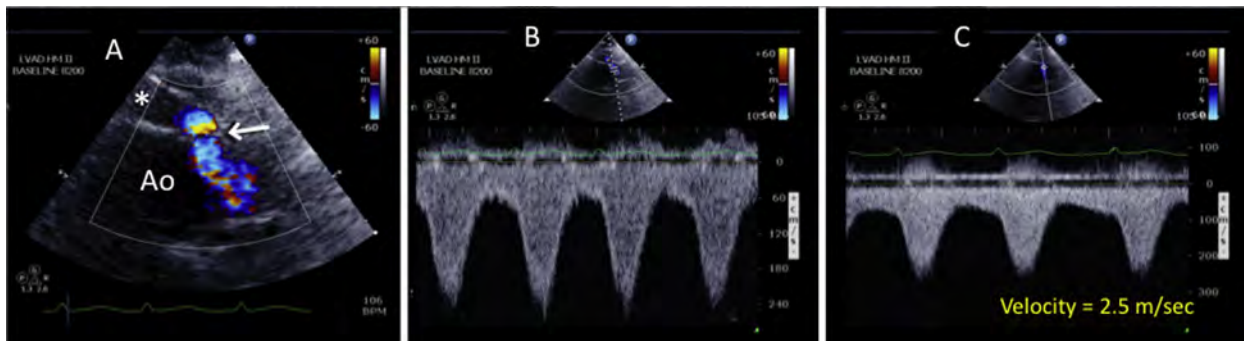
Mild stenosis of the LVAD outflow graft-to-ascending aorta anastomosis site, as assessed by TTE using color and spectral Doppler. (A) 2D image: outflow graft (*). The aliased color-Doppler signal reveals the site of anastomotic stenosis (arrow). See also [Video 32](#). (B) Pulsed-Doppler examination of the anastomotic region shows turbulent flow and an abnormally high peak systolic velocity. (C) Continuous-wave Doppler reveals an abnormally high anastomotic velocity of 2.5 m/sec.
